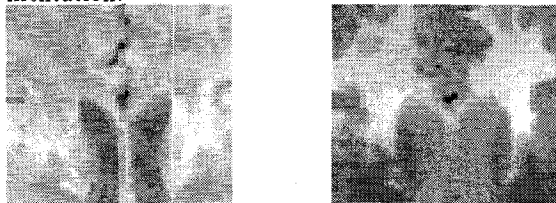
Real patient MR image data
